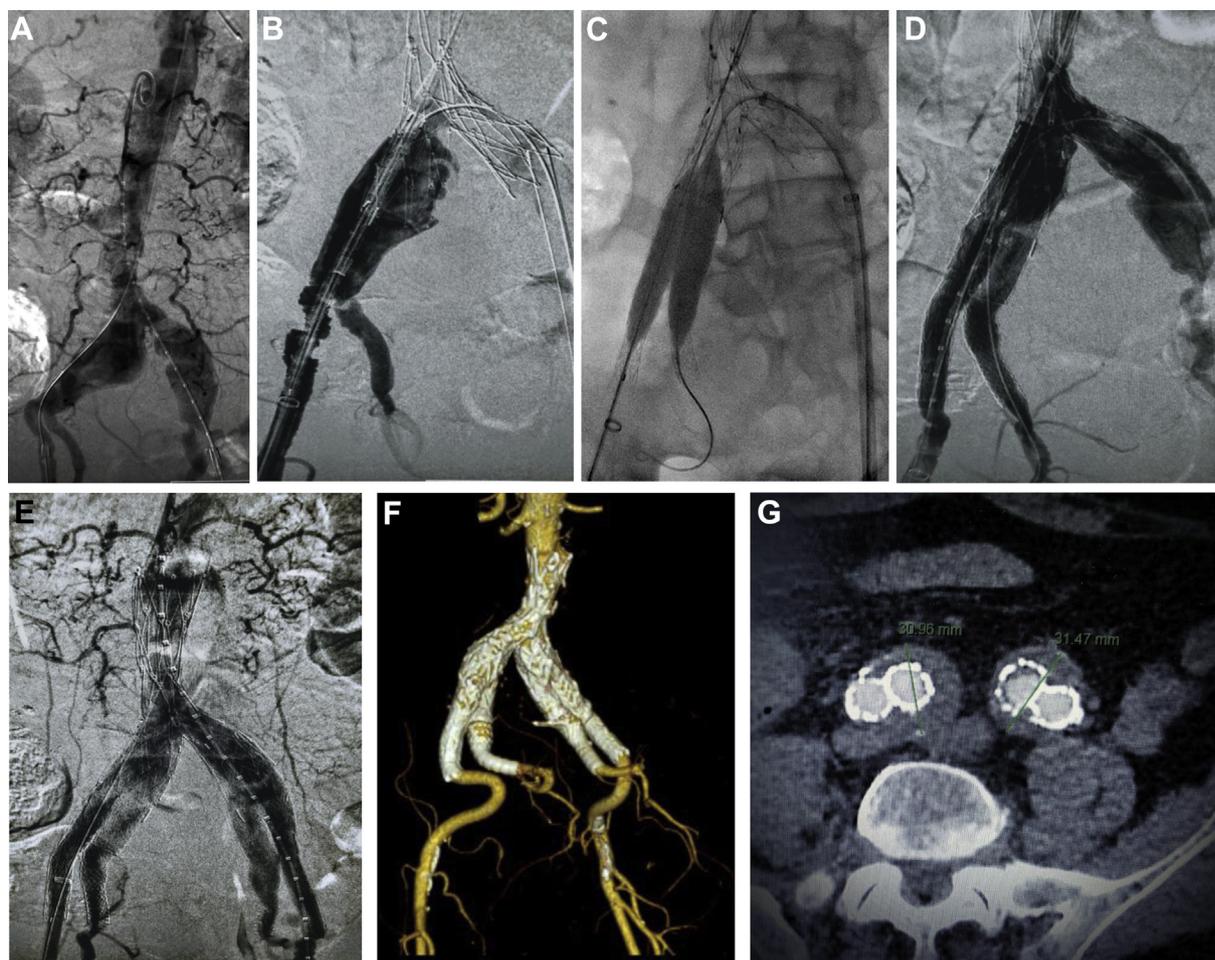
Intraoperative and postoperative imaging. A, Aortogram demonstrating a widely patent aorta and bilateral common iliac artery (CIA) aneurysms extending to the bifurcation with patent internal iliac arteries (IIAs) and external iliac artery (EIA). B, Snaring of the wire proximal to and outside of the AFX endograft and through the bilateral common femoral arteries to facilitate the deployment of the right iliac branch endoprosthesis (IBE). C, Kissing balloon angioplasty of the EIA component of the IBE and the IIA stent to seal the right CIA aneurysm. D, Angiogram demonstrating patency of the unibody endograft and of the right IBE and its IIA and EIA limbs, with no endoleak. E, Completion angiogram showing a widely patent endograft in the aorta, CIAs, EIAs, and IIAs, without endoleak or kinks. F, Three-dimensional reconstruction of the 30-day postoperative computed tomography angiography (CTA) image showing complete exclusion of bilateral CIA aneurysms. G, On 6-month follow-up imaging, the iliac aneurysms had shrunk to approximately 3.1 cm on both sides.
